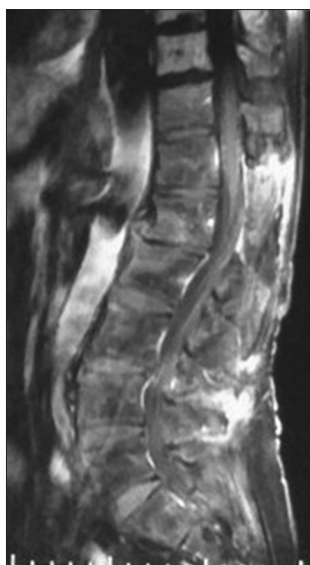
After 6 months of follow up MRI patient does not show any residual or recurrent lesion
